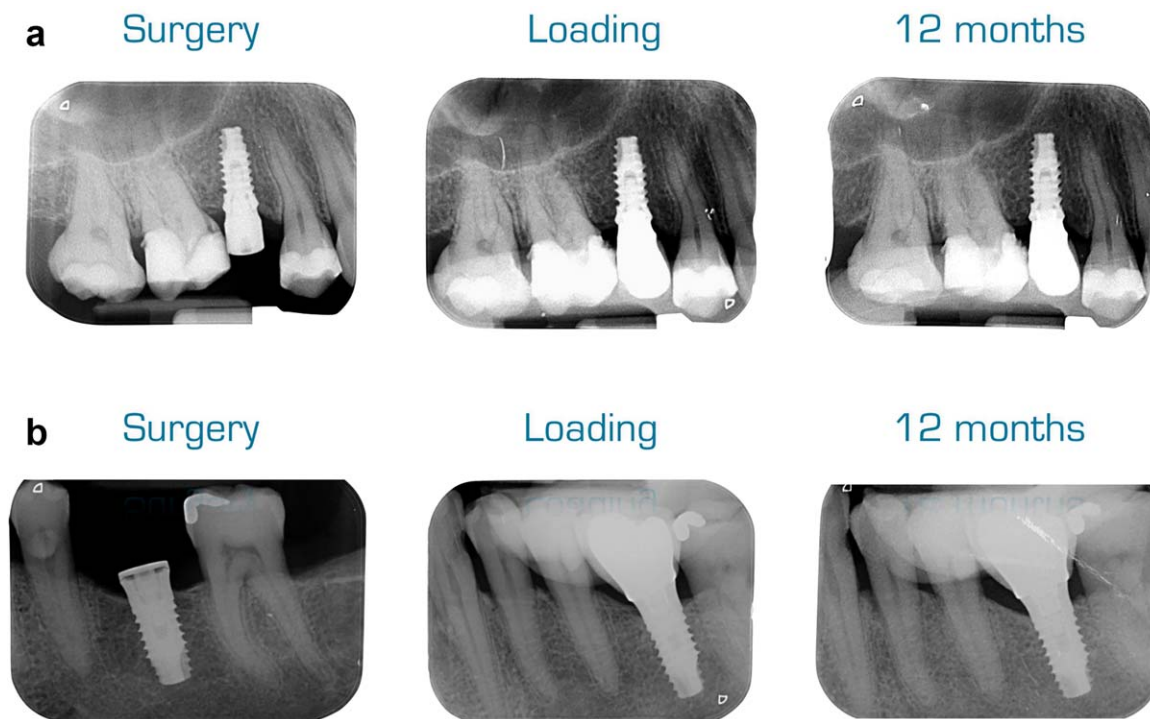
Example of clinical cases: radiographic evaluation
